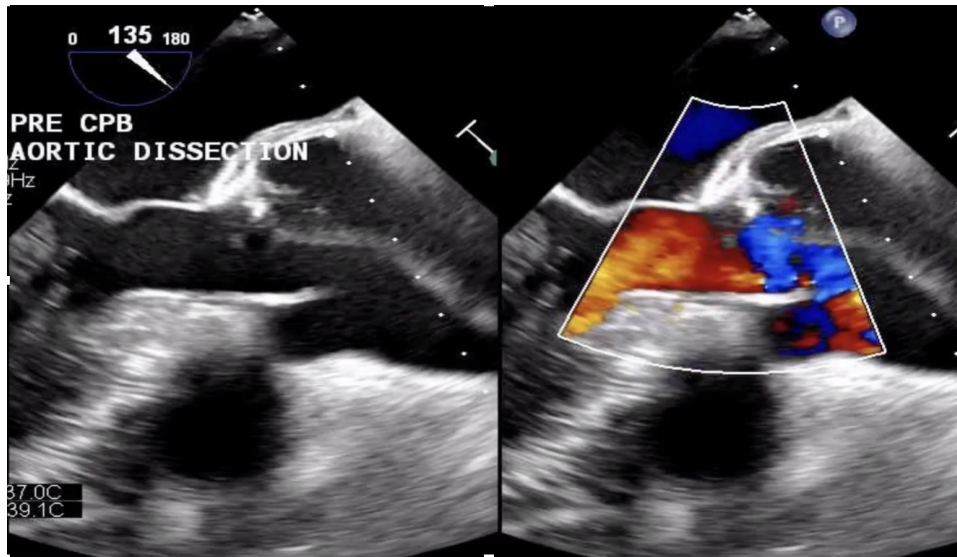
TEE ME Long Axis – Systole: Dissection flap originates within the aortic root just distal to the aortic valve. Color doppler demonstrates antegrade blood flow thru the aortic valve during systole with “lifting” of the dissection flap and enlargement of the true lumen.
